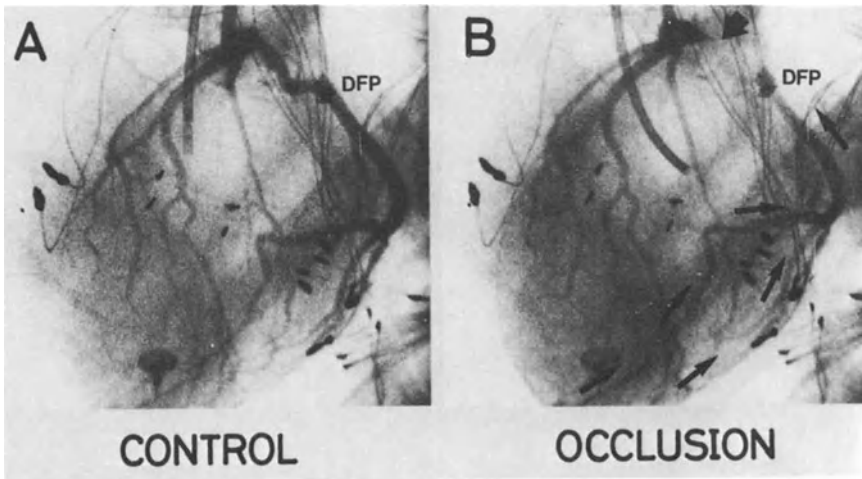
Coronary angiograms before (left side) and after coronary occlusion (right side), in a representative case with well developed collaterals. The large arrow indicates the site of placement of the cuff occluder. DFP, Doppler flow probe.
